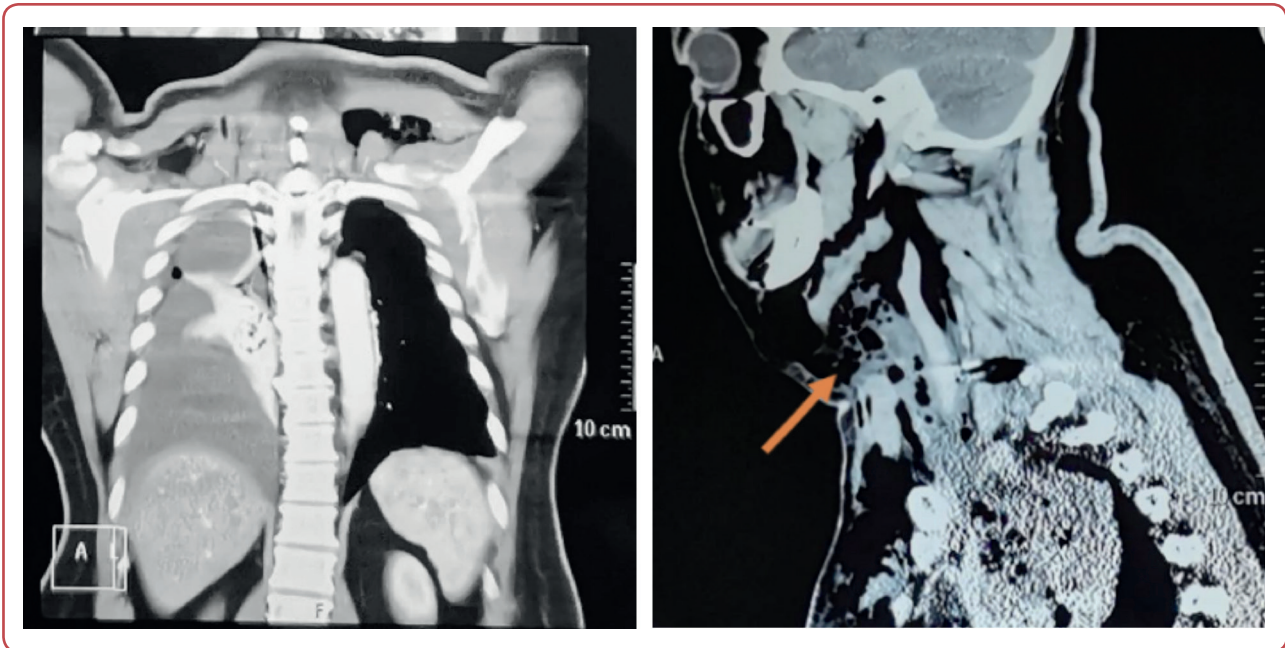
Computed tomography (CT)-scan imaging shows soft tissue swelling with wide emphysema (orange arrow)
